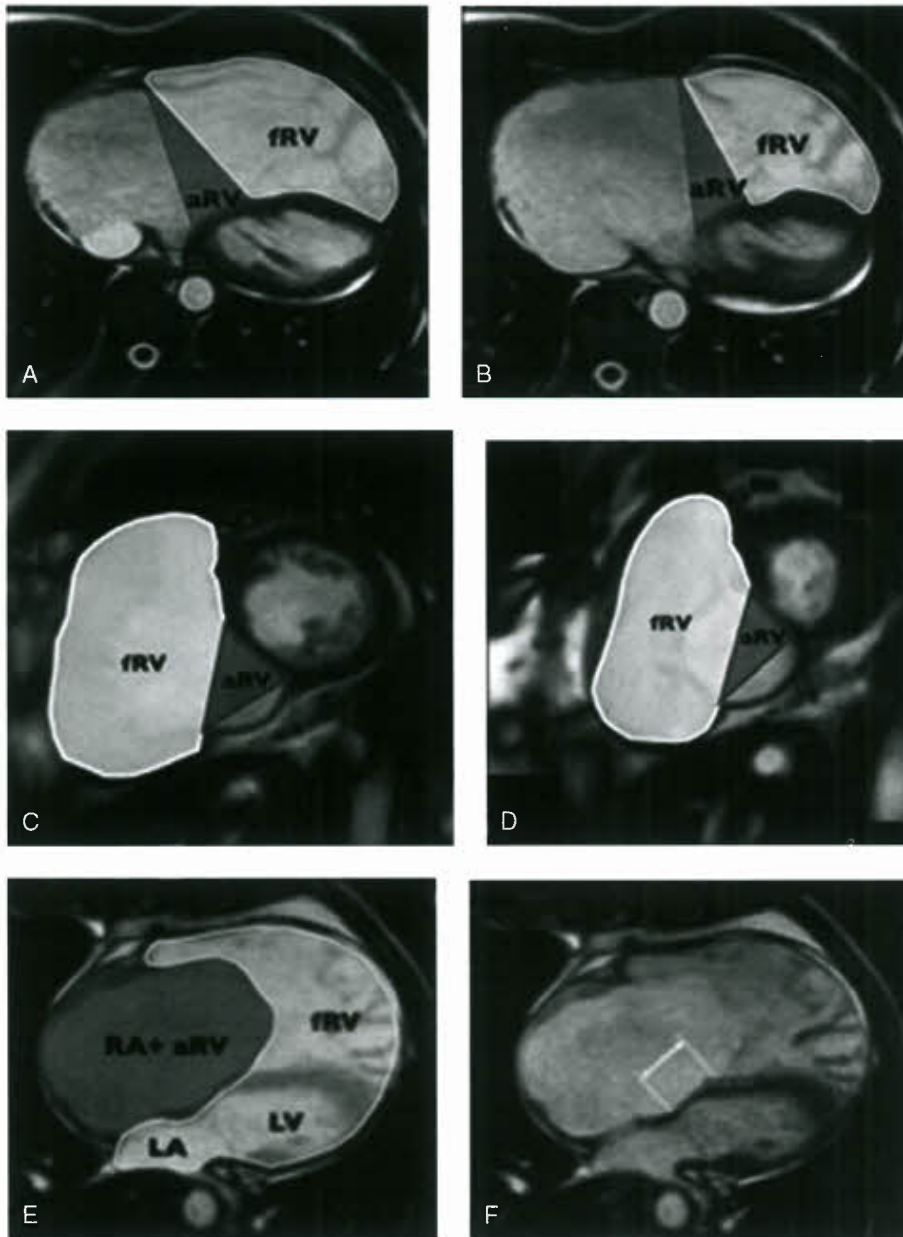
A–F: Cardiac MRI showing: Systolic and diastolic contours of functional RV and ARV in (A,B) axial and (C,D) short-axis views. E: Severity index representing ratio of areas of RA and ARV in numerator and summation of functional RV and left atrium and left ventricular areas in denominator (i.e., severity index = [right atrial area + atrialized right ventricular area]/[functional right ventricular area + left atrial area + left ventricular area]). F: Degree of apical displacement of septal leaflet of TV (in millimeters) measured in ventricular diastole. fRV, functional RV; aRV, atrialized right ventricle; RA, right atrium; LA, left atrium; LV, left ventricle. (Reprinted from Yalonetsky S, et al. Cardiac magnetic resonance imaging and the assessment of ebstein anomaly in adults. *Am J Cardiol* 2011;107(5):767–773, Epub 2011 Jan 19, with permission from Elsevier.)
